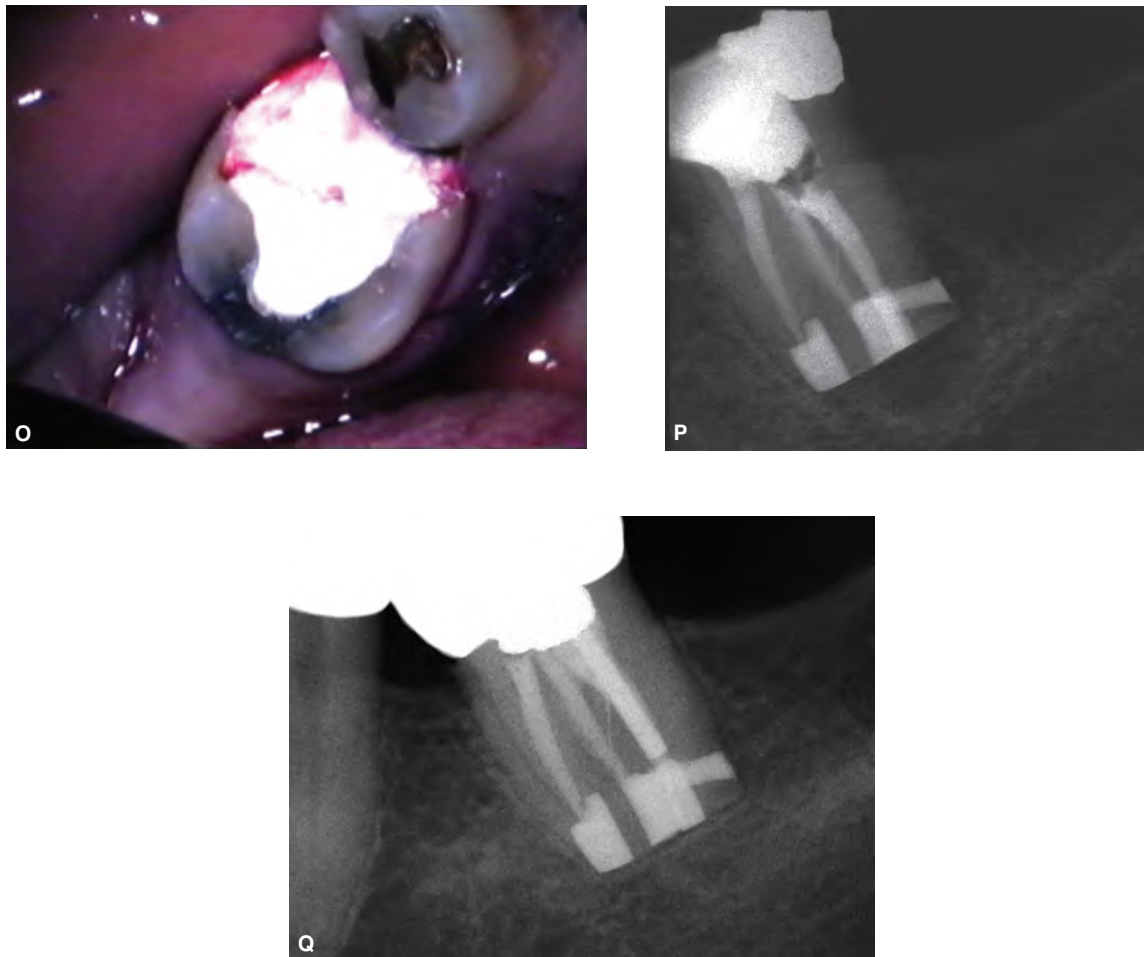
Step-by-step IR of a mandibular left first molar. A. Preoperative radiograph. Note the lesion at the distal aspect of the distal root (arrow) indicating possible presence of a lateral canal. B. The tooth is removed from the socket, and delivered to the basin containing the HBSS. The socket will be flushed with saline, and a sponge placed over the opening. C. The root is carefully examined in all aspects, noting any fractures, lateral canals, lesions or other anomalies. The overextended gutta-percha can be seen protruding through the apical lesion (arrow). The tooth is kept submerged during these, and all subsequent, observations and procedures. D. A low power view of the distal aspect of the distal root reveals the presence of a large lateral canal. Note the withdrawal of the PDL from the vicinity of this canals' foramen (Explorer tip). E. The tooth is positioned so that the root is horizontal and just below the surface of the HBSS. Resection of the root is performed with the root submerged in the fluid. The amount to be removed will be dictated by usual surgical protocols. F. A high power view of the resected surface reveals a "C shaped" anatomy, with an isthmus extending from the MB canal towards the distal root. The root-end preparation of the MB root will need to include this isthmus and any connections with the distal canal. G. The ML canal is being prepared using a #330 bur. The distal and MB canals have already been prepared; the MB preparation can be seen behind the fluid stream. All the preparations are 3 mm deep, prepared in the long axis of the selected canal. H. Preparation of the lateral canal, using the #330 bur. It was prepared to the same depth (3 mm) and centered on the long axis of the canal. Note the denuded root surface corresponding to the lack of PDL and cementum. I. Low power view of the relationship of the lateral and apical root end preparations. Note the PDL "halo" and the hint of gutta-percha in the lateral canal. J. High power view demonstrates the proximity of the MB and distal preparations. The communication can be seen at the depth of the preparations, as well as the communication with the lateral canal. K. Compaction of the root-end filling material (ZOE) into the distal canal resulted in extrusion of the ZOE into the base of the MB preparation; further evidence of the communication. The remaining apical root-end preparations were filled in a similar manner. L. Compaction of the root-end filling material in the apical preparations resulted in the extrusion of the material from the lateral canal; the excess was carved to the cavosurface and removed. M. The root end fillings were examined for extent and finish, with the excess removed prior to replantation. N. The sponge overlying the socket is removed, and the alveolus is thoroughly rinsed with saline or HBSS. This is done to remove any occult blood clots and present a fresh, bleeding surface on the bone. The surrounding gingival tissues are also swabbed with CHX prior to replantation of the tooth. O. The tooth is replanted, and the soft tissues gently readapted to the cervical portion of the tooth. The replantation position is verified radiographically and, if complete, the tooth is splinted (if required) and the occlusion checked before dismissal. P. Immediate postoperative radiograph. The radiolucent areas correspond to the resection space and the lateral lesion. Q. Nine-year postoperative recall radiograph demonstrates complete healing. The tooth is asymptomatic and functional.
